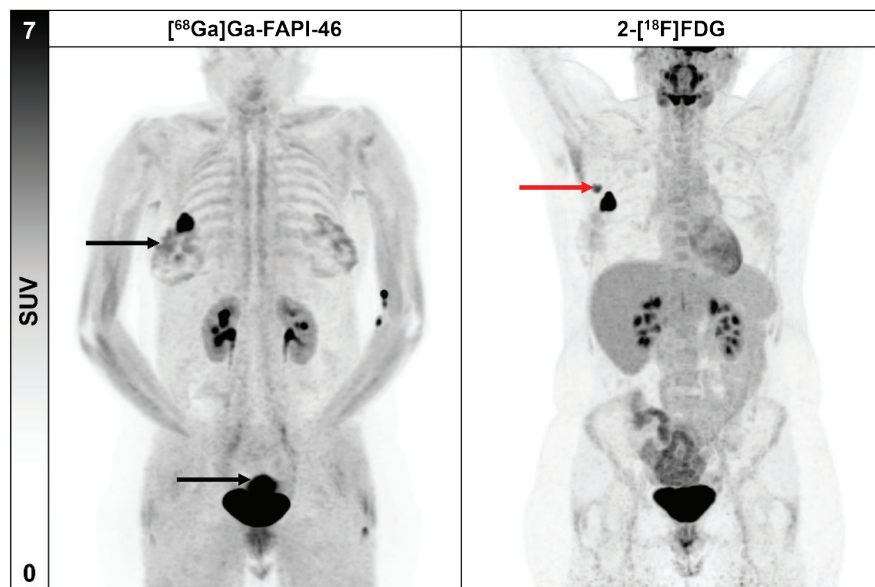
40-year-old female patient with initial diagnosis of triple-negative breast cancer and a false-positive lymph node on 2-[¹⁸F]FDG PET/CT (red arrow). Symmetrical physiological uptake of breast tissue and uterus on [⁶⁸Ga]Ga-FAPI-46 PET/CT (black arrows).
